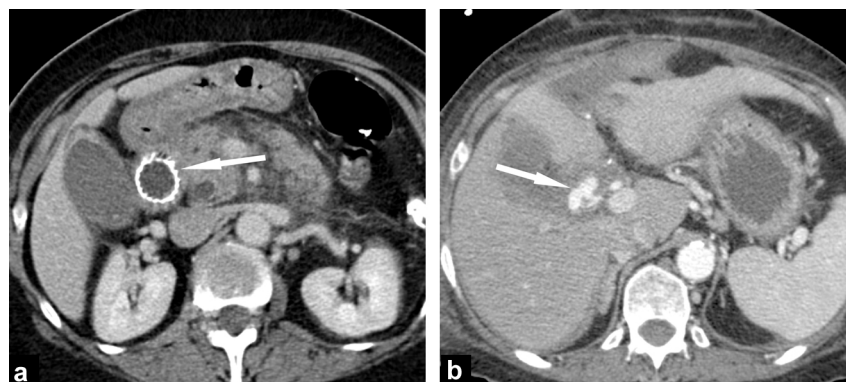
A 70-year-old woman with unresectable adenocarcinoma of the pancreatic head responsible for major dilatation of the jejunum. The patient was palliated with non-covered self-expandable metallic stent (Hanarostent): a: MDCT image in the axial plane shows metallic stent (arrow) in the duodenum. The stent is correctly placed with satisfactory deployment (arrow); b: CT image obtained 17 days after stent placement because of hematemesis shows extravasation of iodinated contrast material (arrow) originating from the right branch of the hepatic artery indicating arterial injury due to stent placement.
